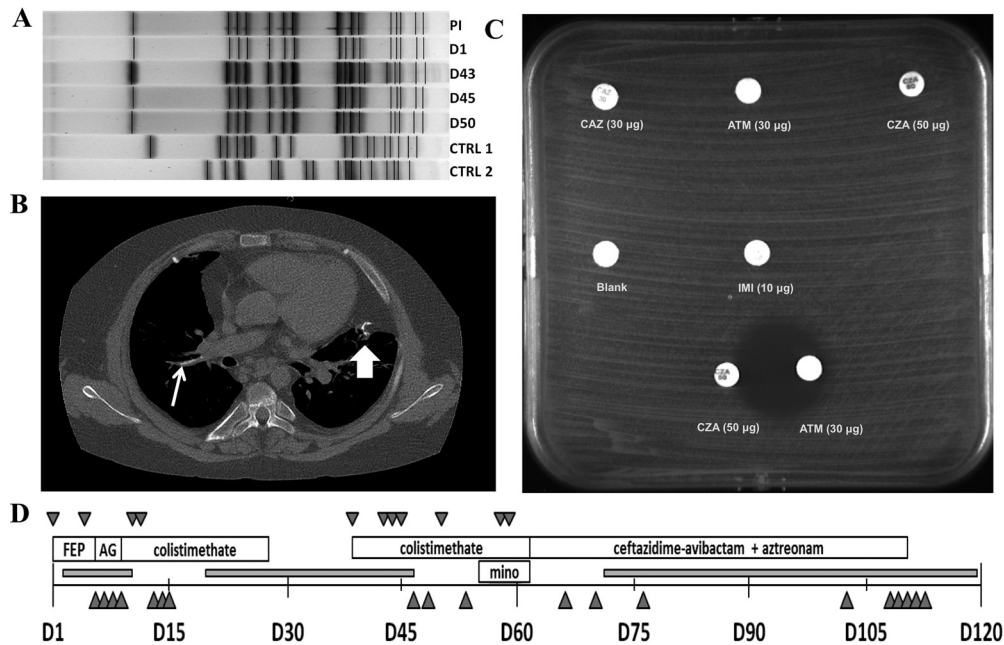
Synopsis of the treatment of bacteremia due to MDR *S. maltophilia*. (A) PFGE of *S. maltophilia* clinical isolates using XbaI. CTRL 1 and 2, contemporaneous control isolates of *S. maltophilia* from different patients. Isolates obtained on day (D1), day 45, and day 50 (primary cluster) are indistinguishable on PFGE. The PI is different by one band, suggesting that it is probably the same strain as the primary cluster. The isolate obtained on day 43 has up to four bands different from the primary cluster, suggesting that it may be related to the primary cluster. The two control clusters are significantly different from the strains isolated from the patient. (B) Noncontrast chest CT scan demonstrating an intravascular calcific lesion. Line arrow, area of calcification in the right pulmonary artery, the suspected site of an endovascular focus. Block arrow, calcification at a prior surgical site of a lung biopsy. (C) Disk diffusion susceptibility testing of the MDR *S. maltophilia* isolate in Mueller-Hinton agar. Note the synergy between CZA and ATM. IMI, imipenem. (D) Time line of bacteremia, antimicrobial therapy, and indwelling vascular devices. FEP, cefepime; AG, aminoglycoside; mino, minocycline. Downward triangles represent positive blood cultures for *S. maltophilia*. Upward triangles represent blood cultures without growth. Gray boxes indicate times when indwelling vascular devices were present.
